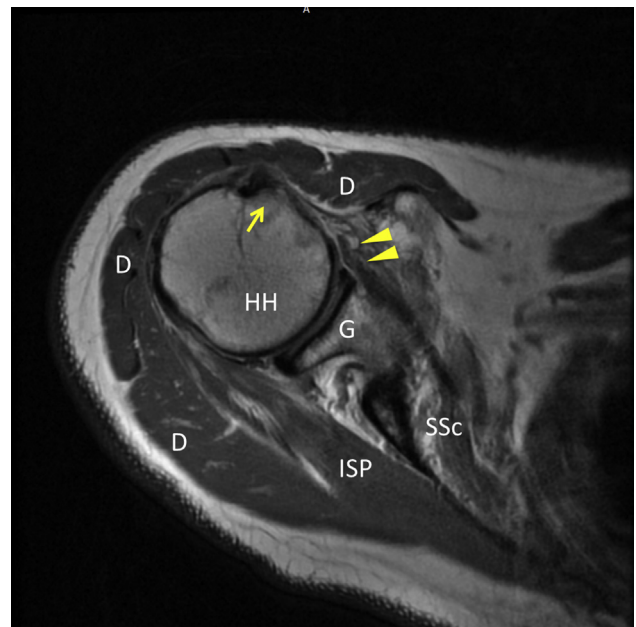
T1 magnetic resonance imaging, axial view, of a right shoulder showing a subscapularis tear. One should note how the subscapularis tendon (arrowheads) has avulsed off the lesser tuberosity (arrow). (D, deltoid muscle; G, glenoid; HH, humeral head; ISP, infraspinatus muscle; SSc, subscapularis muscle.)
